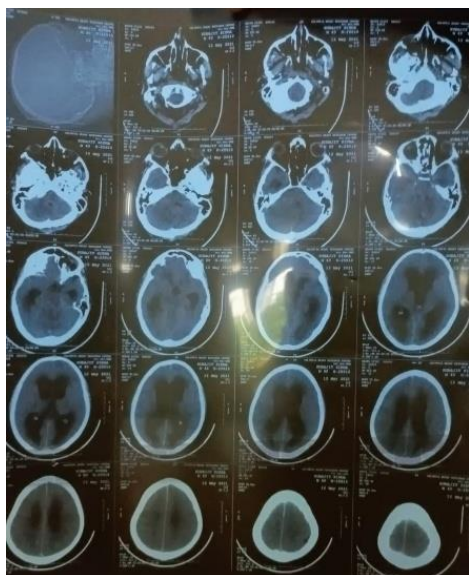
CT Scan of brain showing ischaemic CVA
